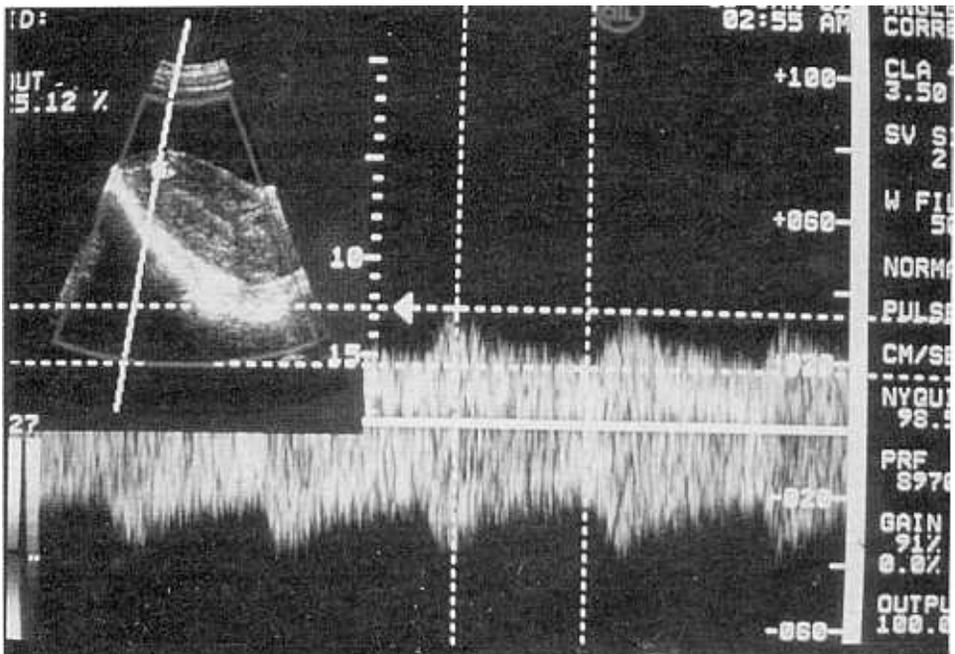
Pulsed Doppler study shows Doppler waveform within the hypochoic area and the S/D ratio was obtained.
